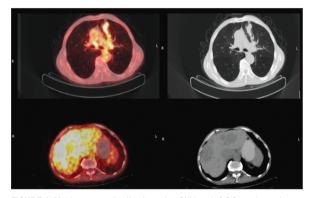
Maximum standardized uptake (SUV_{max}): 3.3 fluorodeoxyglucose (FDG) uptake is present in the left lung upper lobe anterior, nodular lesions in the area extending anteriorly from the hilar region, and reticulonodular density areas close to the paramediastinum. There is SUV_{max}: 4.6 FDG uptake in peripheral and heterogeneous hypodense lesions observed in multiple areas in the liver.
